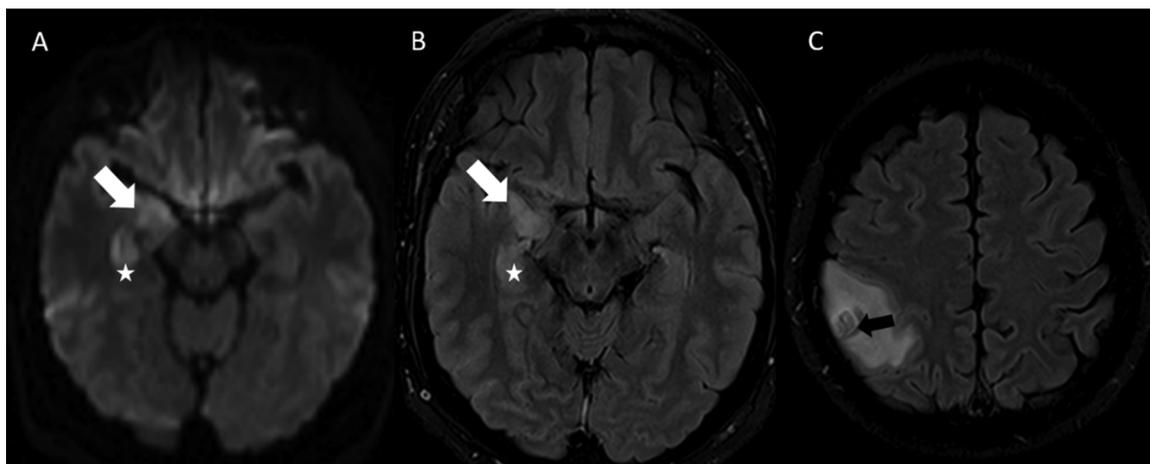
Brain MRI in a patient with status epilepticus. A hyperintense area is seen on diffusion-weighted images (A and B), affecting the amygdala (arrow) and hippocampus (star) on the right side, related to cytotoxic edema. A right parietal metastatic lesion (arrow in C) surrounded by vasogenic edema is seen on an axial T2-FLAIR image.
